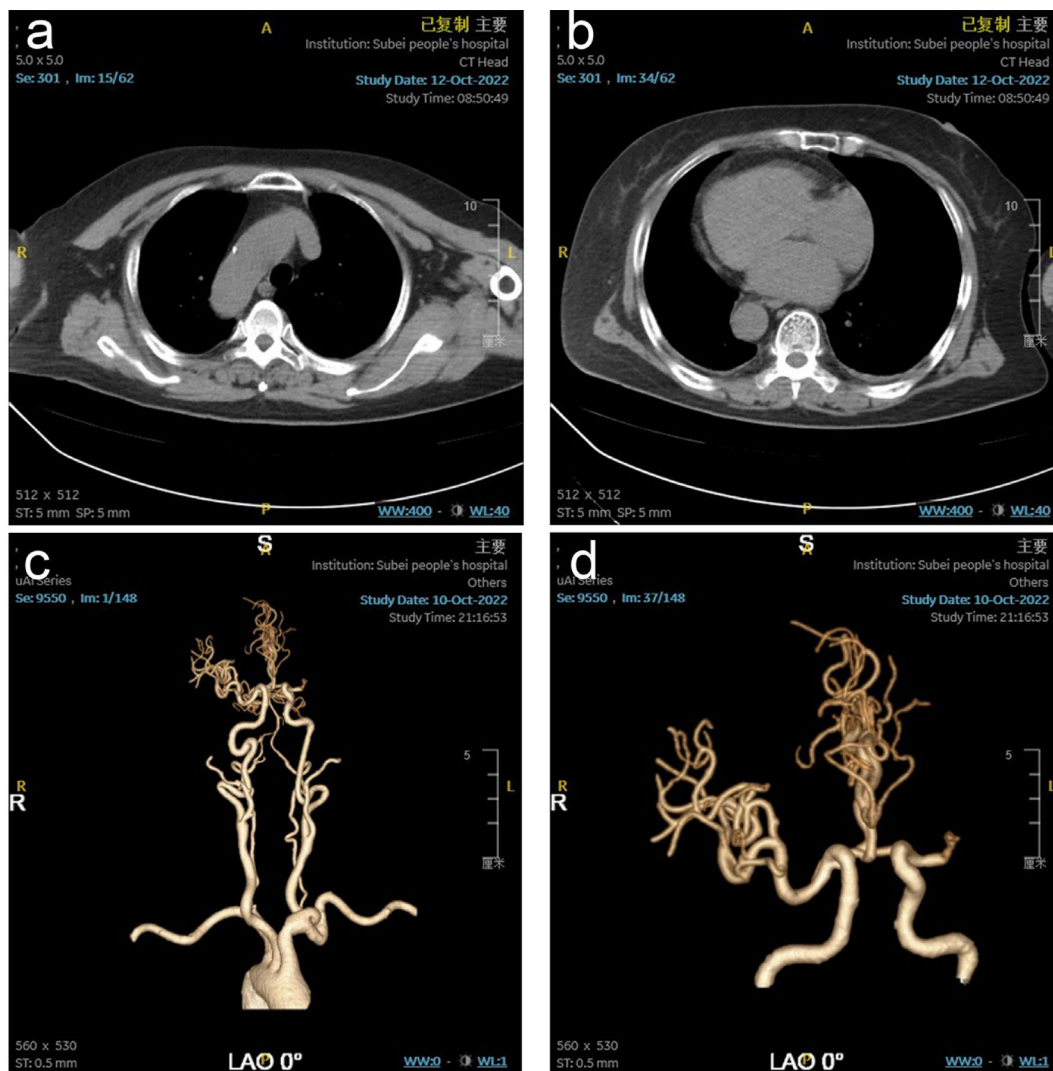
Relevant investigations were completed after admission: a. Chest CT imaging showing the right aortic arch. b. Chest CT imaging showing mirror image changes in the mediastinum with a bias to the right. c. Head and carotid CTA showing right aortic arch and left middle cerebral artery occlusion. d. Left middle cerebral artery occlusion.
